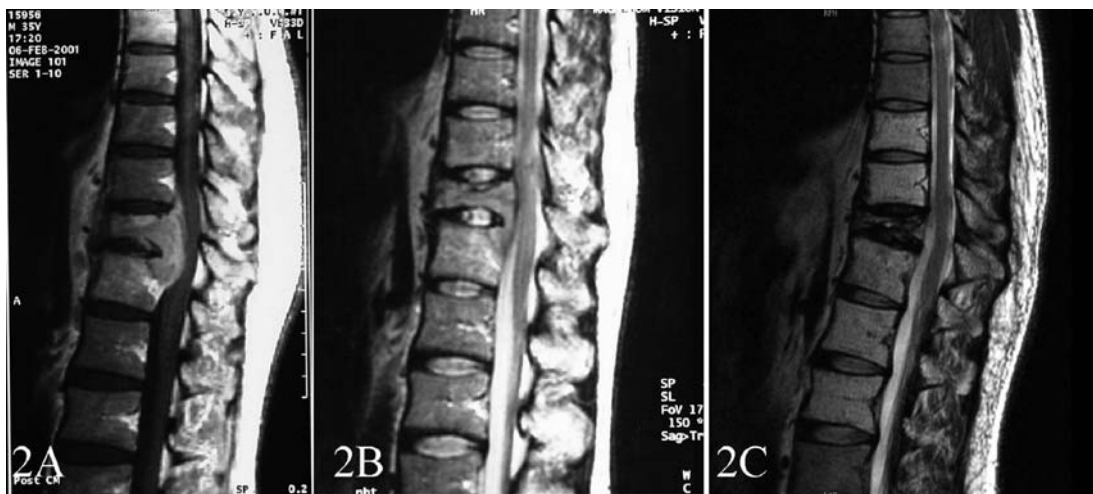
Results of primary non-Hodgkin's lymphoma of T11-12 treated by radiotherapy and chemotherapy (case 10). (A) MRI views (T1-weighted with gadolinium enhanced image) show the prominent extension of soft tissue into the spinal canal and compression of the spinal cord. (B) MRI views (T2-weighted) show spinal cord is decompressed 24 days after radiotherapy and chemotherapy. (C) MRI views (T2-weighted) show spinal cord is decompressed completely and no evidence of tumor exists 6 years after treatment.
